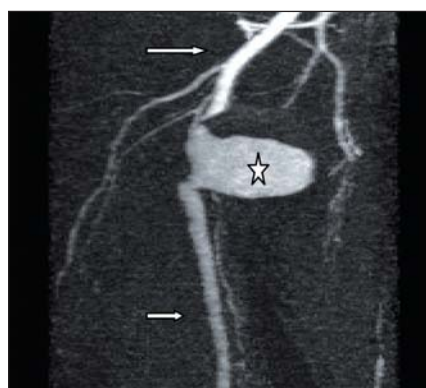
MRI with intravenous contrast injection of the right brachial artery (arrows) showing extravasation of contrast in the PSA (star).
